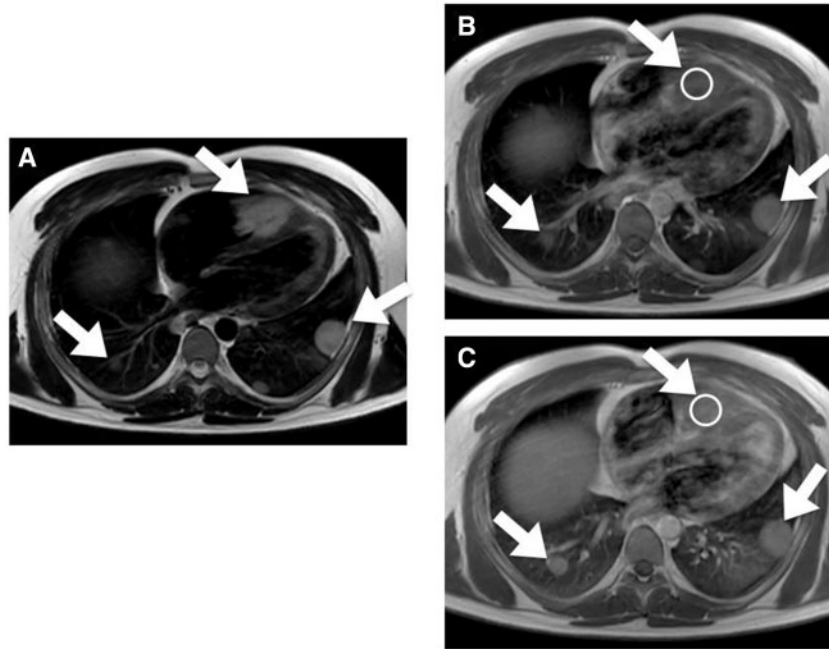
Magnetic resonance imaging in four chambers. T2-weighted turbo spin echo black blood sequence (A) showing a hyperintense signal of the right ventricular mass (upper white arrow). Additionally, metastases of both the left and right lung are displayed (lower white arrows). The T1-weighted turbo spin echo black blood sequence before (B) and after (C) contrast media application demonstrates a considerable signal increase (signal intensity 680 vs. 981) of the lesion (upper white arrows).
